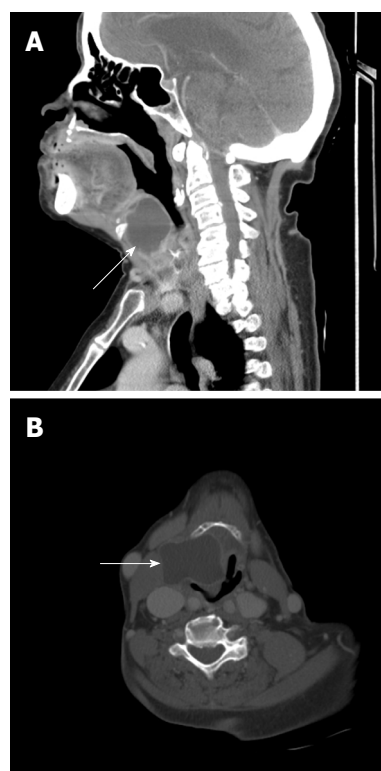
Computed tomography neck soft tissue. A: Sagittal view of neck soft tissue (arrow); B: Transverse view of neck soft tissue (arrow).
